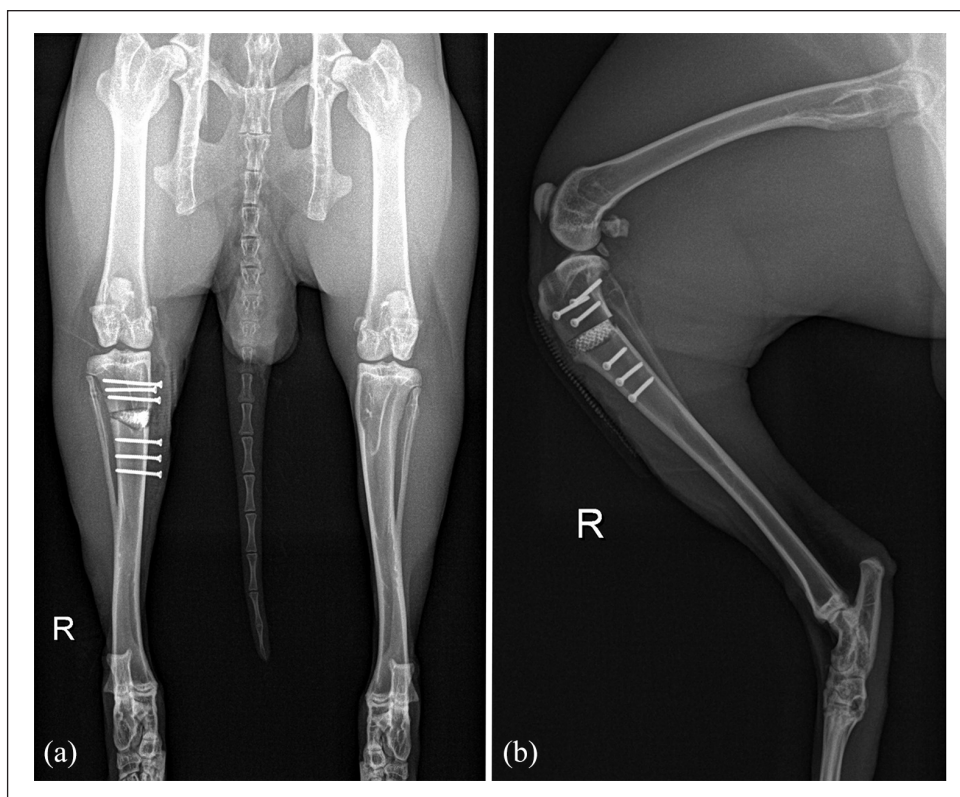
X-ray images in (a) craniocaudal and (b) mediolateral view post-op (the plate is generally not visible in radiodiagnostic images).
